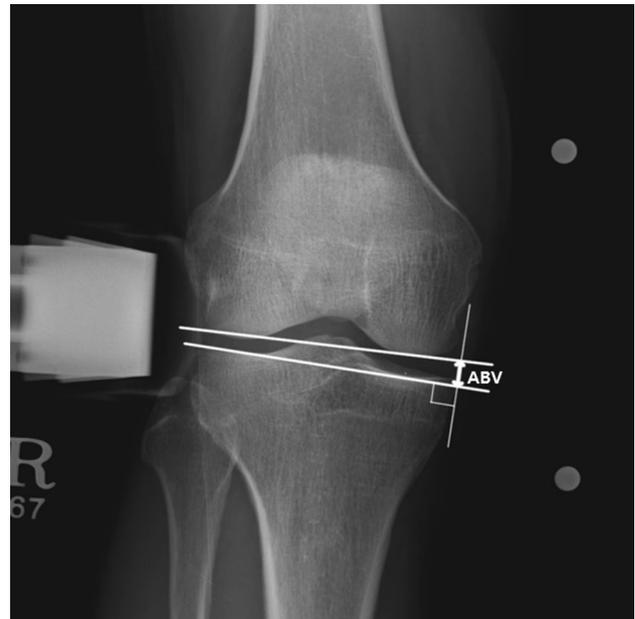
The amount of valgus laxity was measured using the method described by Jacobsen et al. [21] with correction of each measurement made by utilizing a 10 cm magnetic bar taken along with each radiograph
